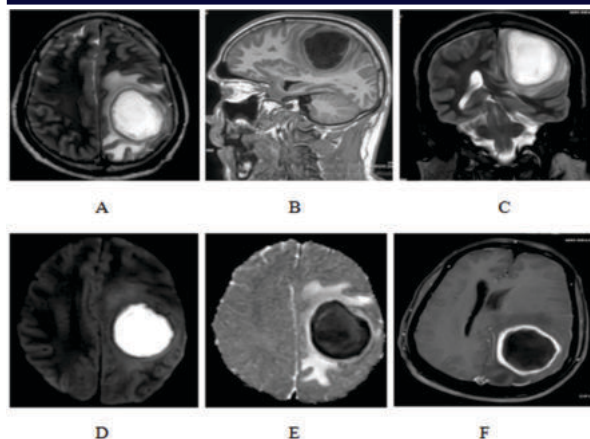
A and C – T2 WI images showed hyper intense lesion in the left parietal lobe with surrounding edema. B- T1 WI corresponding area showing in the hypo intensity. D and E – DWI and ADC showing restriction in the DWI with low signal intensity in the ADC with ADC value of $0.6 \times 10^{-3} \text{ mm}^2/\text{sec}$ F- Post contrast image showing peripheral thin smooth rim enhancement.
